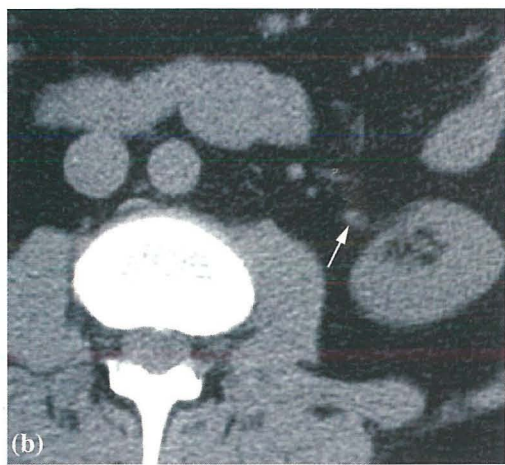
(b). Extrarenal pelvis. Axial CT scan obtained at a slightly lower level shows that the extrarenal pelvis tapers rapidly to a normal proximal ureter that is not dilated (arrow).
